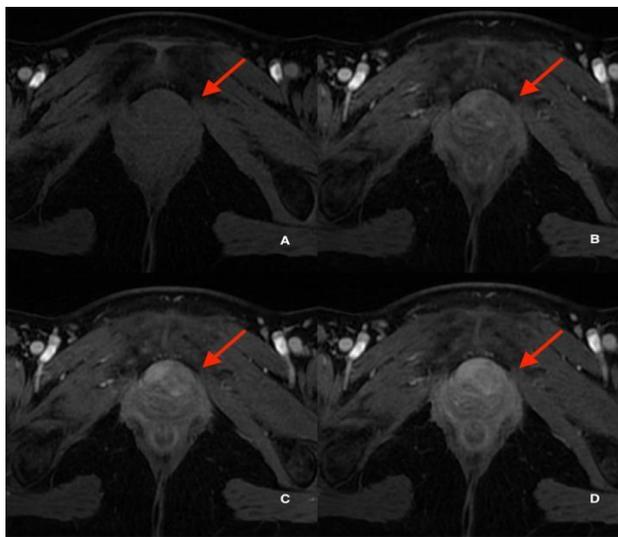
T1-weighted images with fat saturation in the basal (A), arterial (B), venous (C) and late (D) phase. Urethral leiomyoma appears isointense to the muscles on the basal phase (A). After Gadolinium administration, it shows poor enhancement in the arterial phase (B), showing a progressive and uniform contrast enhancement on the venous (C) and late (D) phase.
